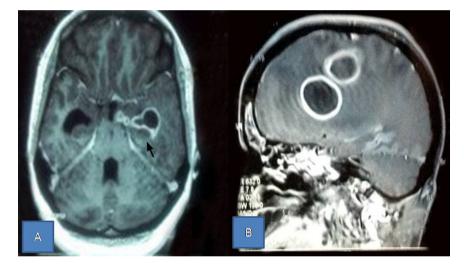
(A) Axial section MRI brain T1 contrast study showing ring enhancing lesions of left temporal lobe (arrow) with ependymal enhancement of temporal horn of left lateral ventricle with hydrocephalus. (B) Sagittal section MRI brain T1 contrast image showing ring enhancing lesions of right parietal lobe with central low signal intensity s/o abscesses (patient was HIV positive).
